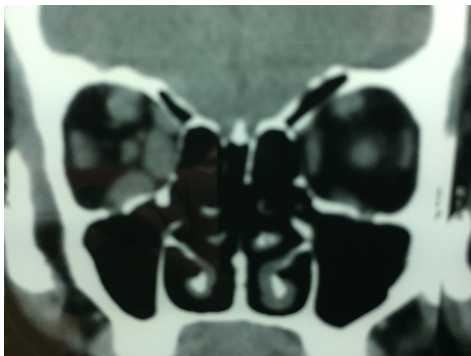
Coronal view of computed tomography scan of the above patient with Thyroid Orbitopathy: Note the extraocular muscle thickening more pronounced in the right (OD) eye. Also note the more pronounced thickening of the inferior and medial rectus as compared to the superior and lateral rectus(OD)
